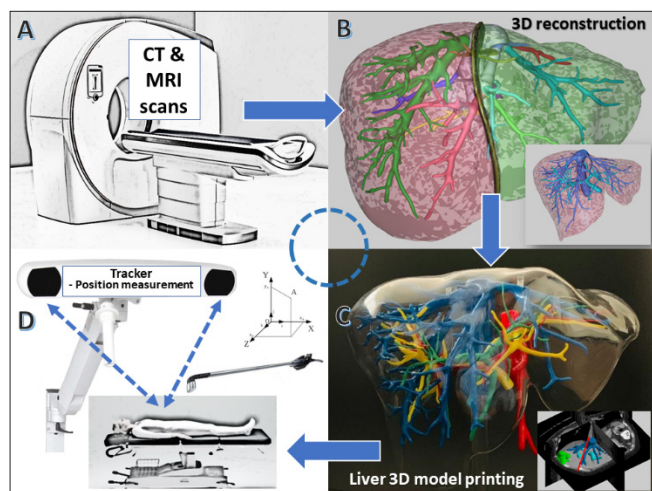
Advances in pre- and intra-operative surgical planning for liver surgery. A - Pre-operative high resolution cross sectioning imaging. B - 3D reconstruction of the pre-operative scans. C - 3D printing of liver model based on CT/MRI scans. D - Intra-operative surgical navigation tracking.
